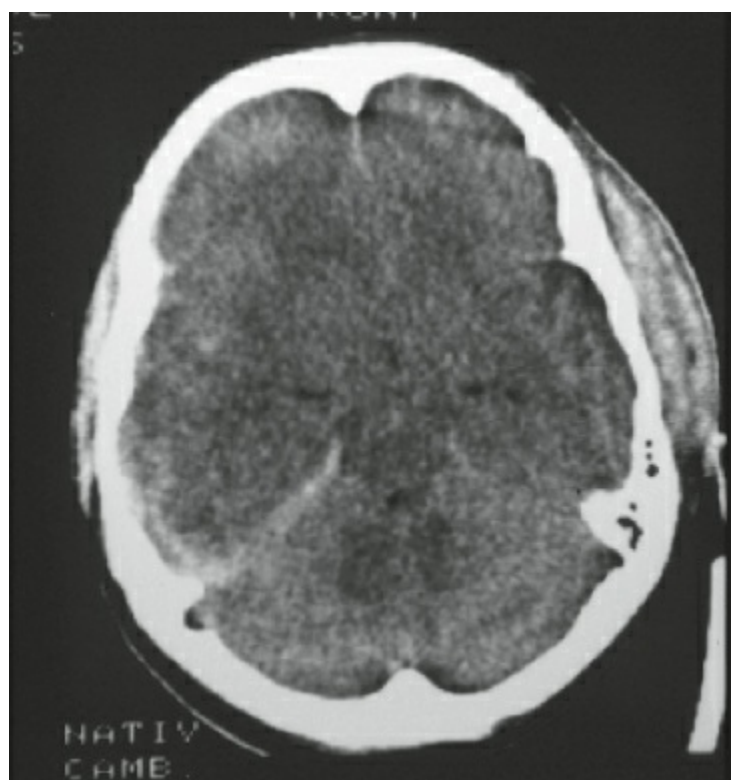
A computed tomography scan that is highly predictive of intracranial hypertension. The basilar cisterns are obliterated and the sulci are flattened.
